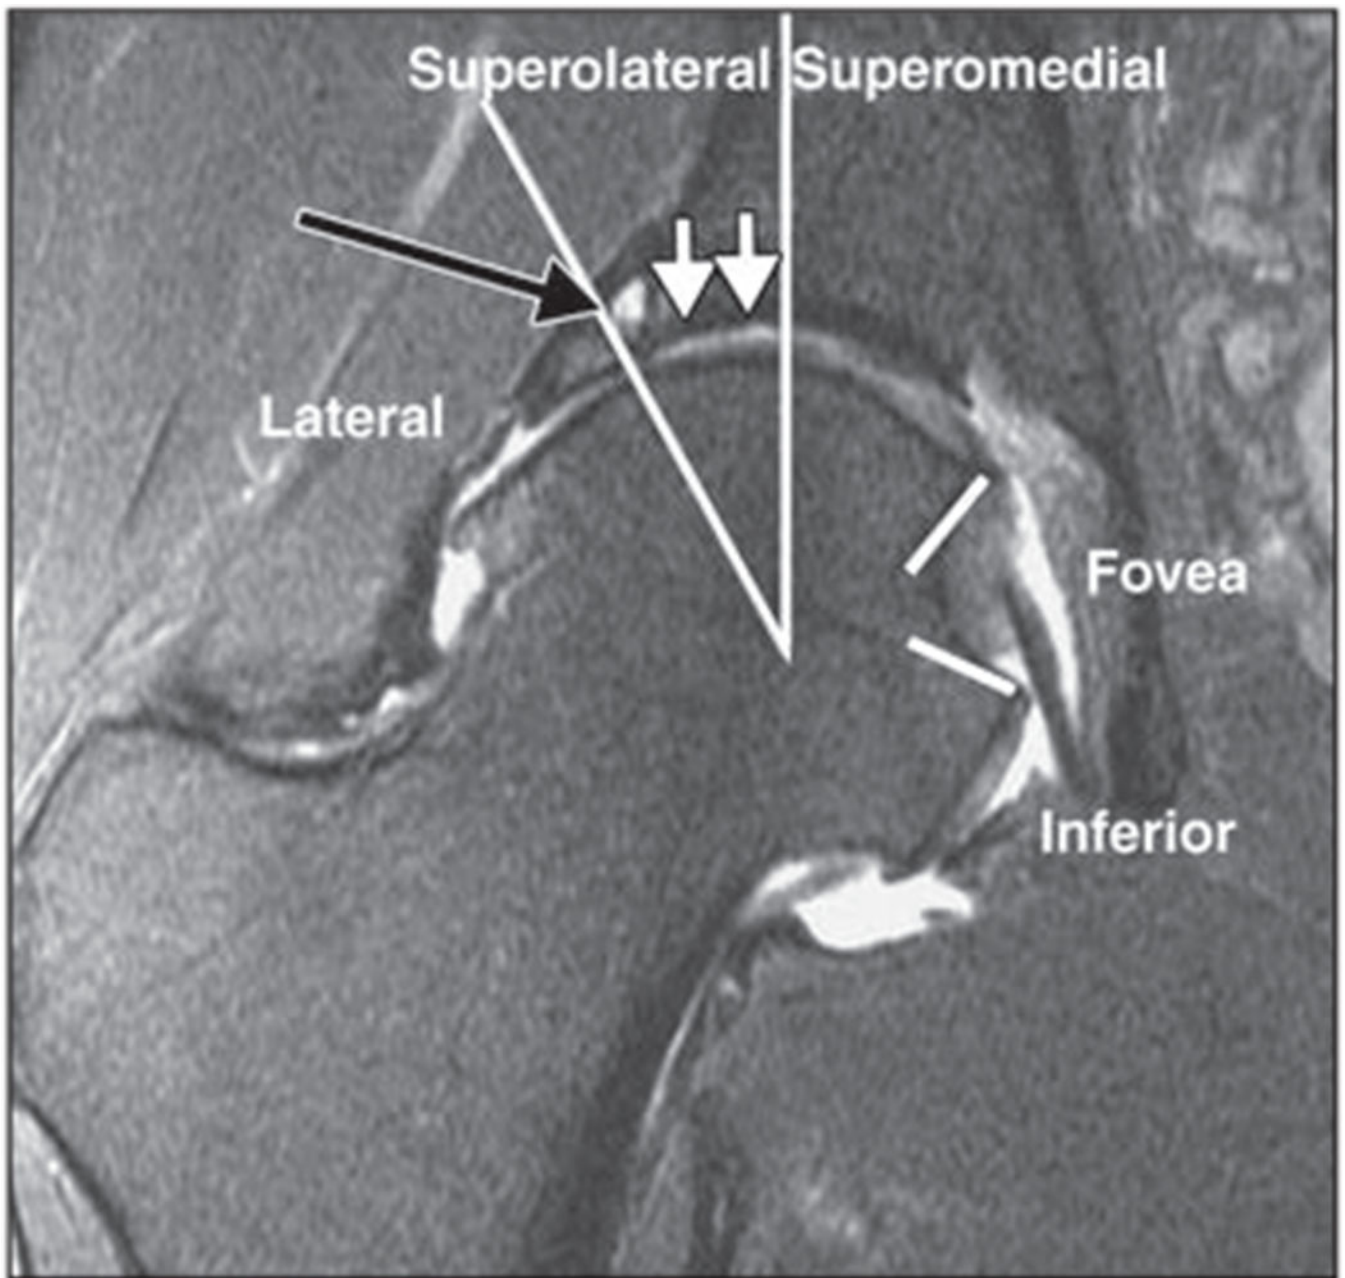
Coronal 2D fat-suppressed intermediate-weighted fast spin-echo image of right hip of 42-year-old woman with degenerative disease of hip and femoroacetabular impingement. According to score obtained using SHOMRI (scoring hip osteoarthritis with MRI) scoring system [21], femoral cartilage is separated into four subregions and acetabular cartilage into three subregions in coronal image. There is full-thickness acetabular cartilage loss with diameter of 10 mm (*white arrows*) in superolateral subregion, which would be scored as grade 2 lesion according to SHOMRI. There is also subchondral cyst (*black arrow*) in superolateral region. Findings were arthroscopically confirmed. Long lines show separate lateral, superolateral, and superomedial regions, and short lines = indicate foveal regions.
